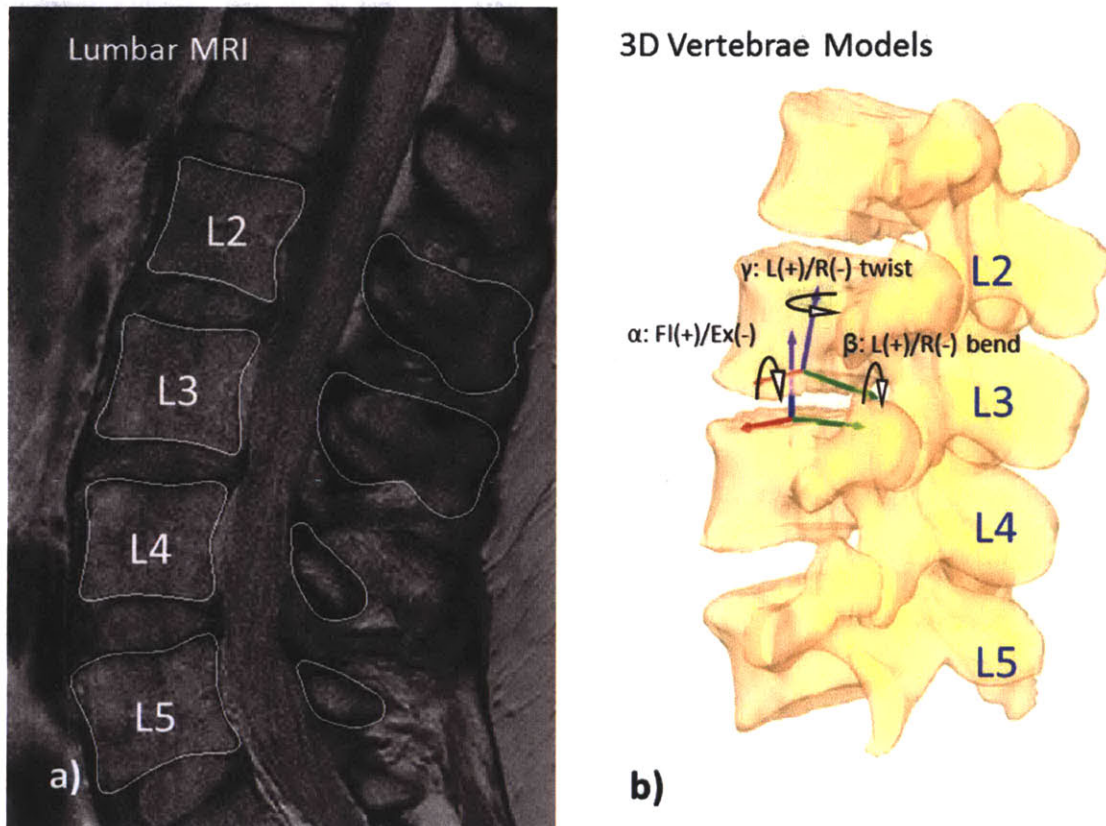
a) Vertebral segmentation on MRI. b) 3D reconstructed vertebrae models from MRI and local coordinate system.
